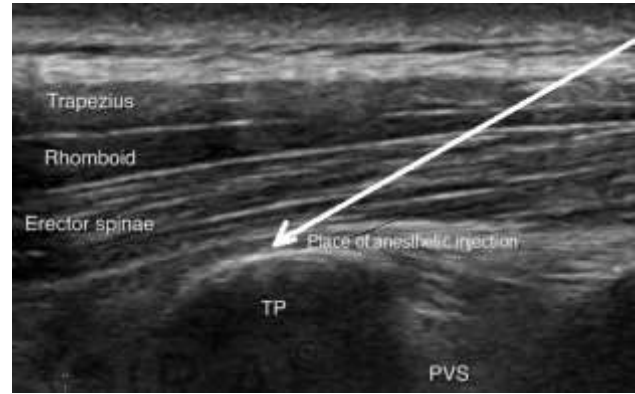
Ultrasound visualization of the place of needle positioning and local anesthetic injection
